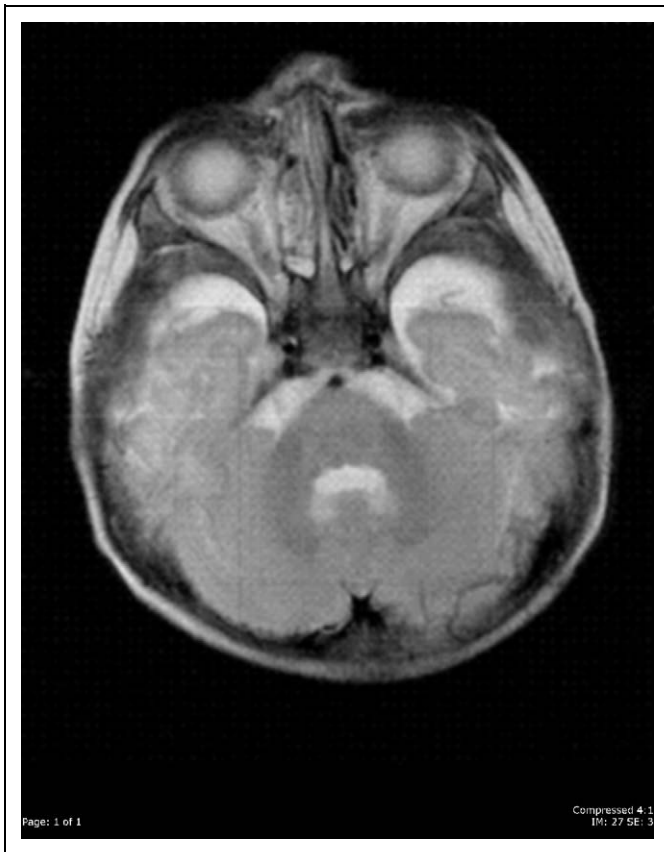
Case 1. Axial T2-weighted magnetic resonance imaging on day 3 of admission to the emergency department. Image shows subacute subdural hematomas at the level of posterior fossa and temporal poles.
